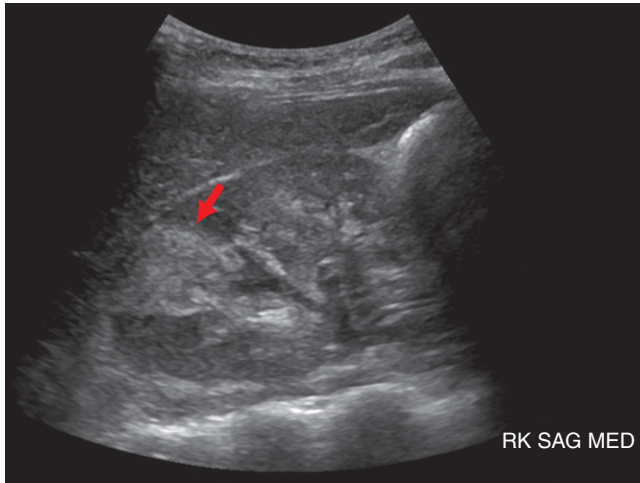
Sagittal ultrasound without color demonstrates well-demarcated echogenic region seen within this superior pole of the right kidney (arrow).
